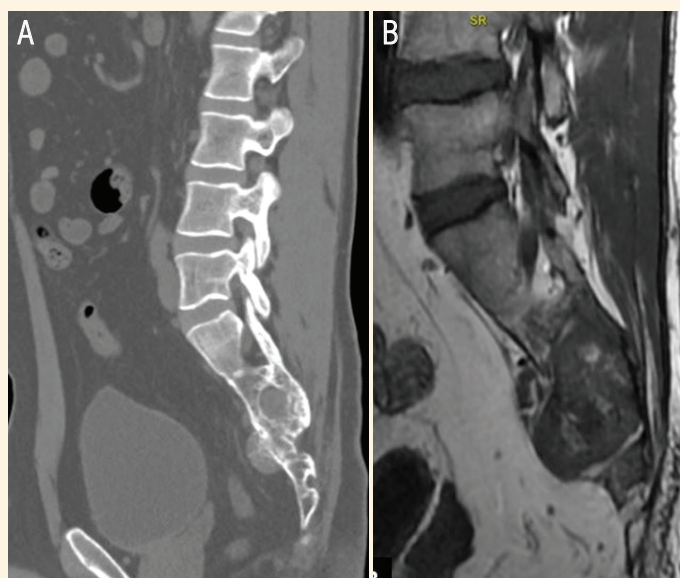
Imaging scans of the spine of a 28-year-old male. A: Sagittal computed tomography bone window image showing an expansile soft tissue density lytic lesion involving the S2 to S5 sacral vertebrae with a presacral bulge and extension into sacral foramina. B: Sagittal T1-weighted image showing a well-margined expansile, predominantly hypointense lesion involving the S2 to S5 vertebrae.
